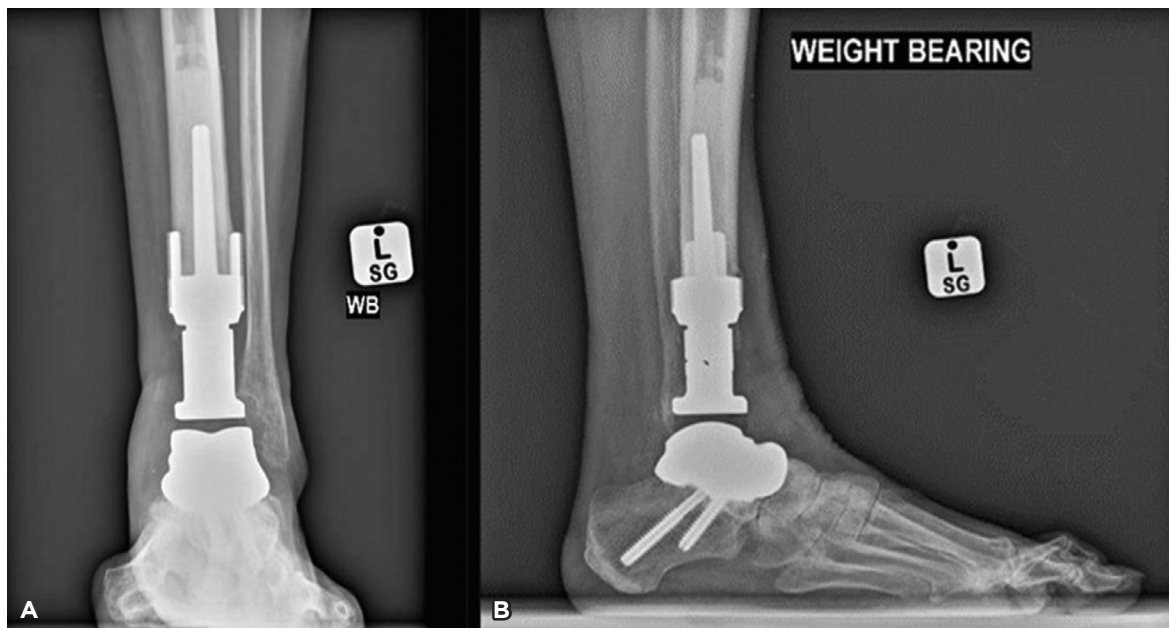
Postoperative radiographs (A = Anteroposterior and B = Lateral) showing the custom total talus and cemented distal tibia replacement with good alignment and fixation.
